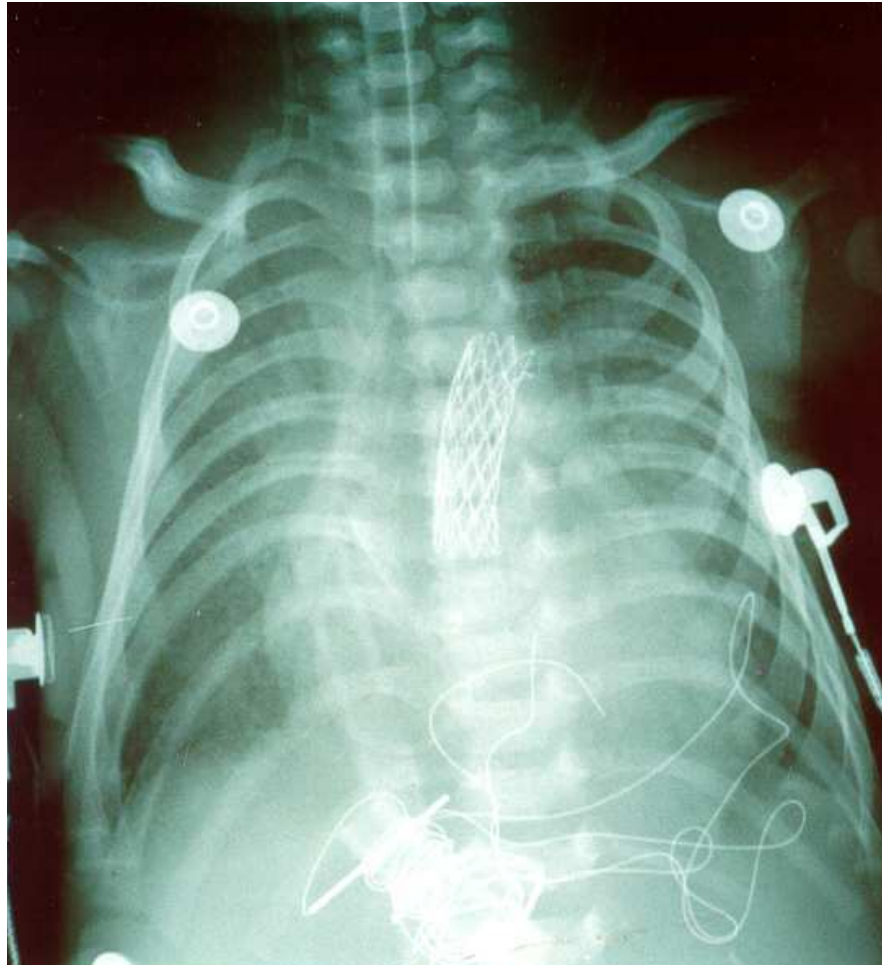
Postoperative chest X-ray after hybrid procedure, showing stent implanted into the ductus arteriosus
